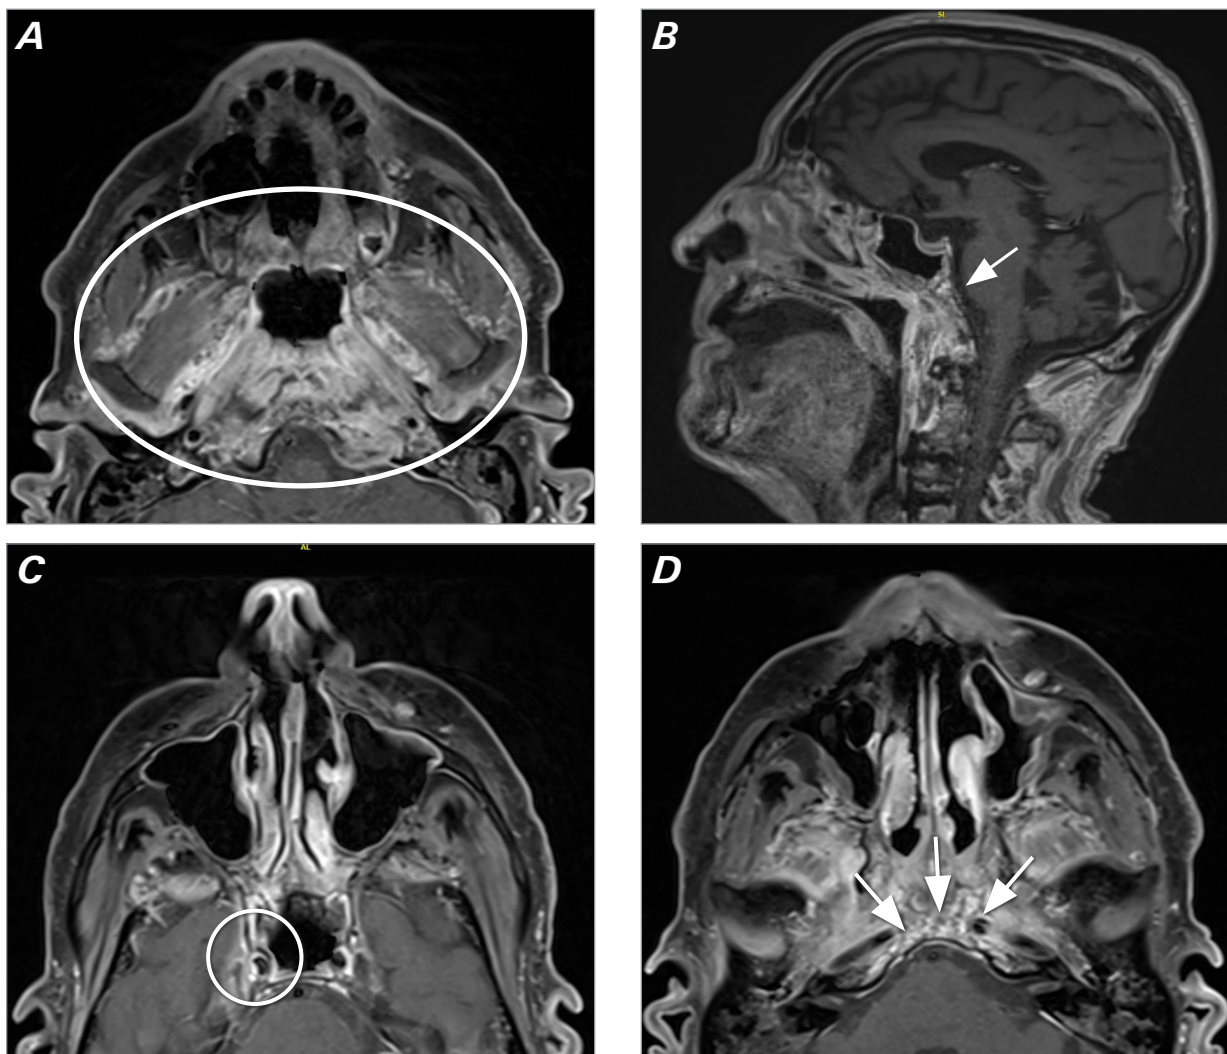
T1-weighted brain magnetic resonance images demonstrating A) edematous changes involving the masticator space of the pterygoid muscles bilaterally (oval); B) oropharyngeal invasion of amyloidoma (arrow); C) enhancement of the bilateral Meckel caves through which the trigeminal nerves traverse, with the right Meckel cave enhancing more than the left (circle); and D) enhancement of the clivus and skull base (arrows), suggesting invasion of amyloidoma into bony structures.
